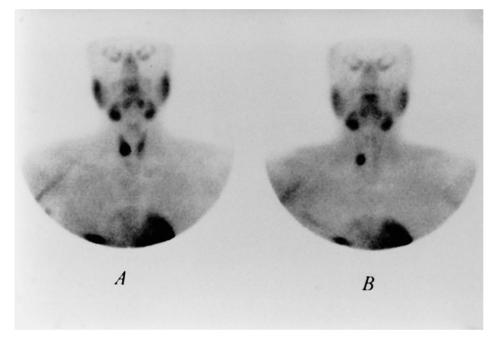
Double-phase ^{99m}Tc-sestamibi parathyroid scintigraphy. Images at 15 min (A) and 2 h (B) post injection. A focal uptake which remains after thyroid clearance (scored as marked uptake) is clearly seen in the inferior right lobe. A pathological gland weighing 1950 mg was removed
